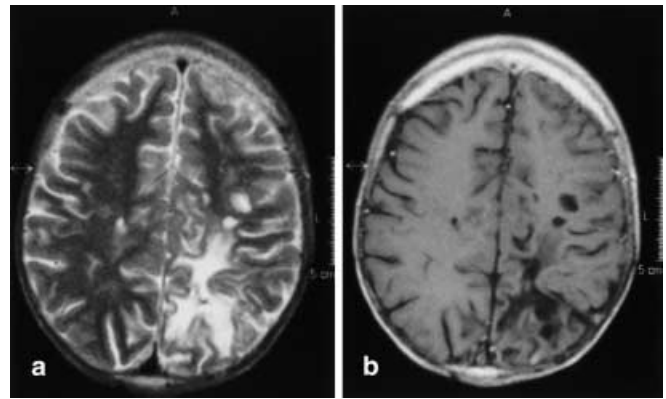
Cystic lesions. Cystic lesions adjacent to the parenchymal defect of the left parietal lobe on T2-weighted images (a) in a 14-year-old boy and a follow-up of 6 years after surgery, and combined chemo-/radiotherapy of a supratentorial PNET. The lesions are well defined on T1-weighted images (b)
